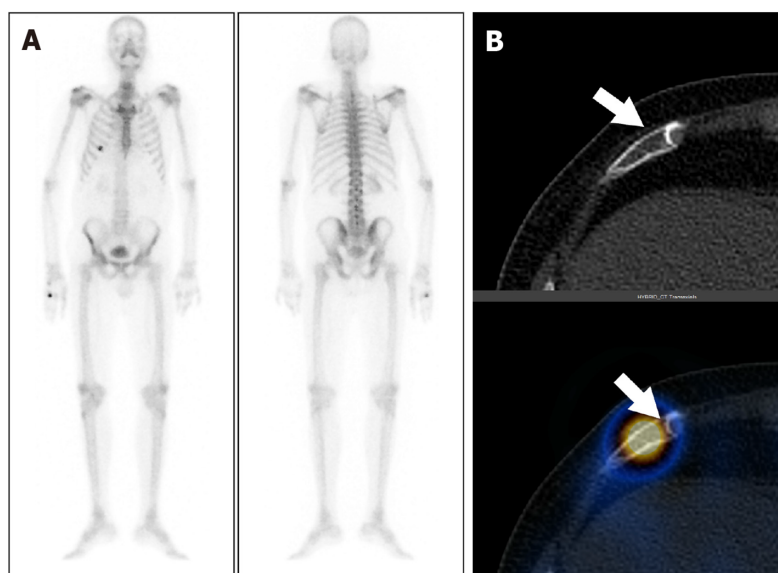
A 66-year-old male with carcinoma of the prostate and serum prostate-specific antigen of 23.3 ng/mL. A: Staging with whole body bone scintigraphy show focal areas of increased tracer uptake involving the right 6th rib; B: Axial computed tomography (CT) and fused single photon emission computed tomography-CT images show tracer localization to the right 6th rib anteriorly with a fracture line (arrow). The uptake was thus secondary to rib fracture post traumatic. There was no other abnormal uptake anywhere in the bones on whole body study.
